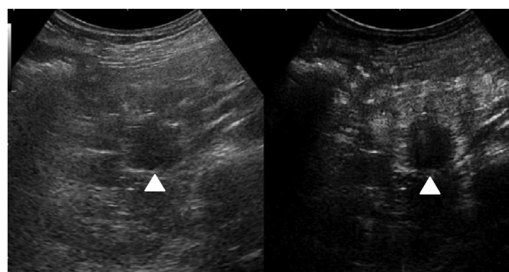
Representative case of pancreatic cancer with hypo-enhancement pattern by contrast-enhanced transabdominal ultrasound. A hypo-echoic lesion 10 mm in size (arrowheads) was depicted in the pancreas using fundamental B-mode ultrasound observation systems (ARIETTA 850; Hitachi Aloka Medical, Ltd, Tokyo, Japan) (left). After reconstitution with 2 mL of sterile water for injection, 0.7 mL of Sonazoid (GE Healthcare, Tokyo, Japan) was administered through a peripheral vein. Contrast-enhanced transabdominal ultrasound (right) revealed that the lesion (arrowheads) was hypo-enhancing compared with the surrounding pancreatic tissue during the late phase.
